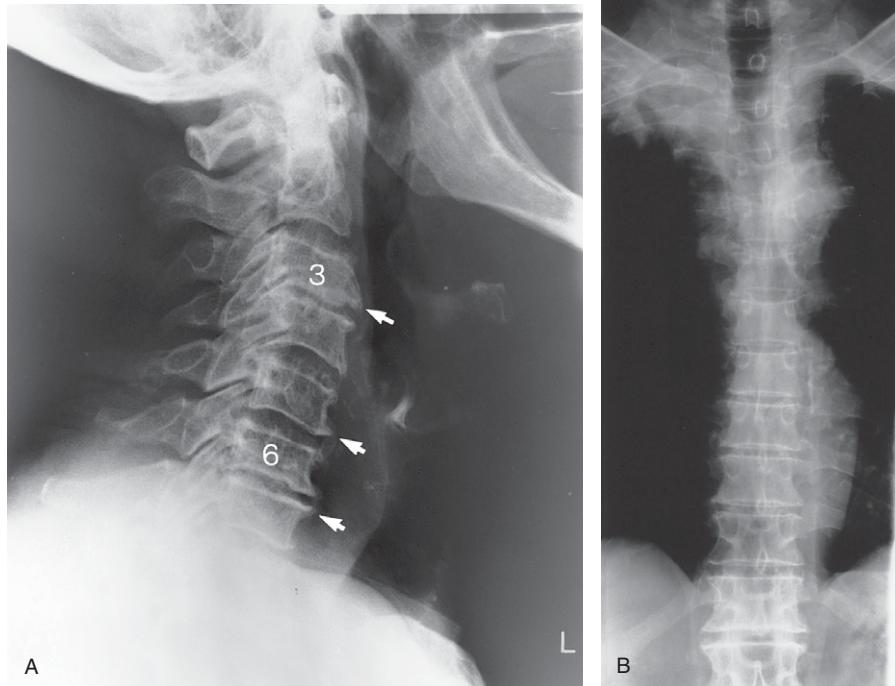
(A) Cervical spine lateral plain X-ray image showing 'extensive spondylitic changes throughout the cervical spine with disc narrowing and marginal osteophyte formation. The disc narrowing is most severe at the C3–4 and the C6–7 levels and the marginal osteophyte formation is also most prominent at these levels' (e.g. white arrows). (B) An anteroposterior thoracic spine plain X-ray view showing minor degenerative osteophytes forming at all thoracic levels and a suspicion of a space-occupying lesion in the right lung apex.
